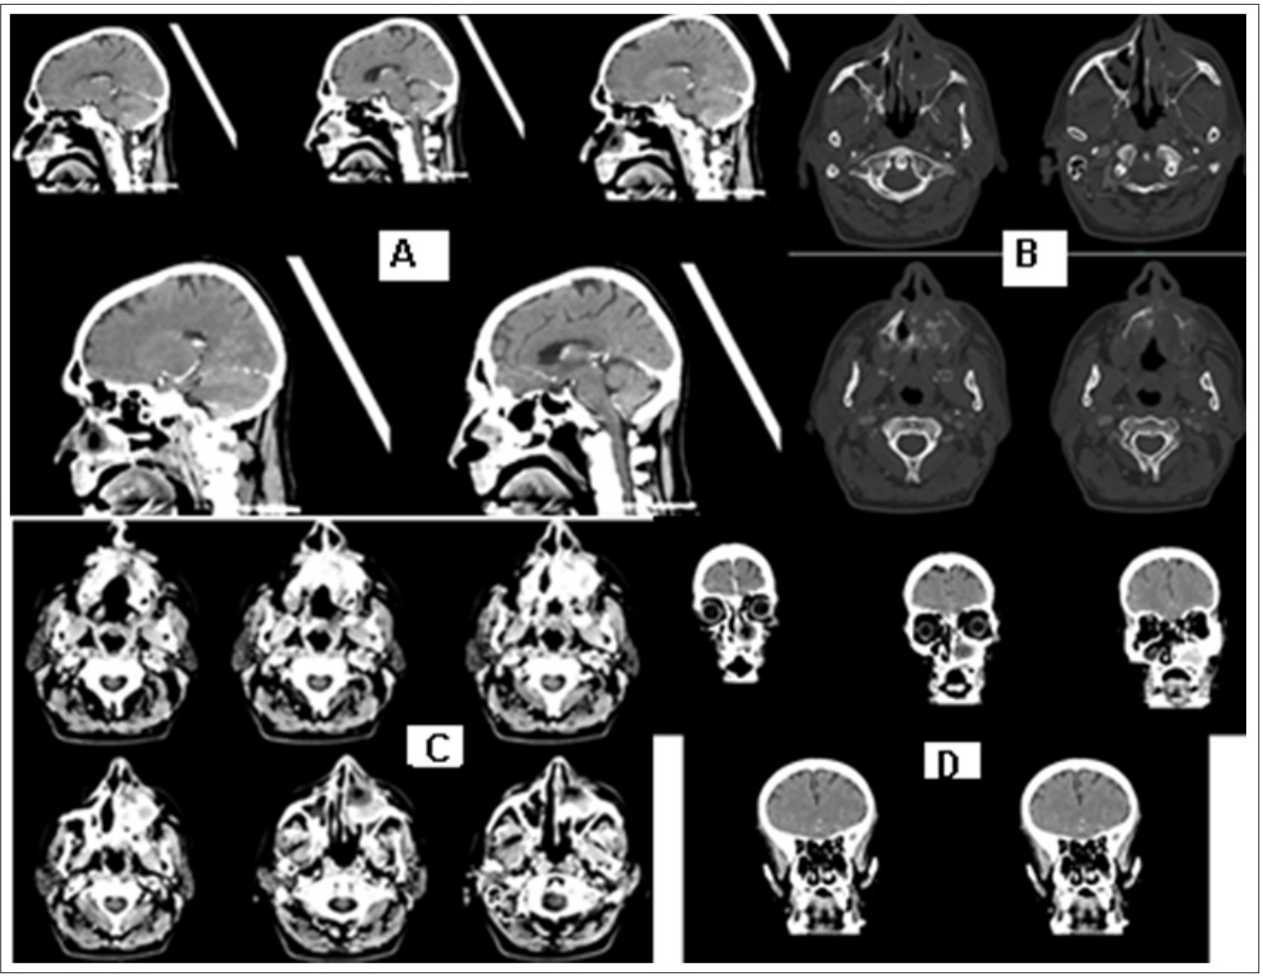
Preoperative contrast-enhanced cranial CT with axial slices (A) and coronal slices (B) revealed mixed osteolytic and osteosclerotic lesion of the left maxillary sinus and left nasal cavity with a heterogeneous structure. Presence of a soft tissue component, associated with bone expansion and erosion.
